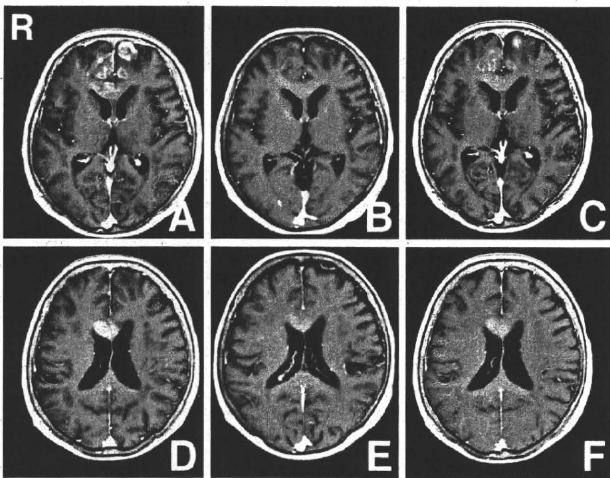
Initial (A, D) and two follow-up magnetic resonance images 3 days (B, E) and 10 days (C, F) after bevacizumab treatment of a 68-year-old female patient with glioblastoma showing the heterogeneously enhanced tumor regressed 3 days after bevacizumab treatment, but reappeared 7 days later.
